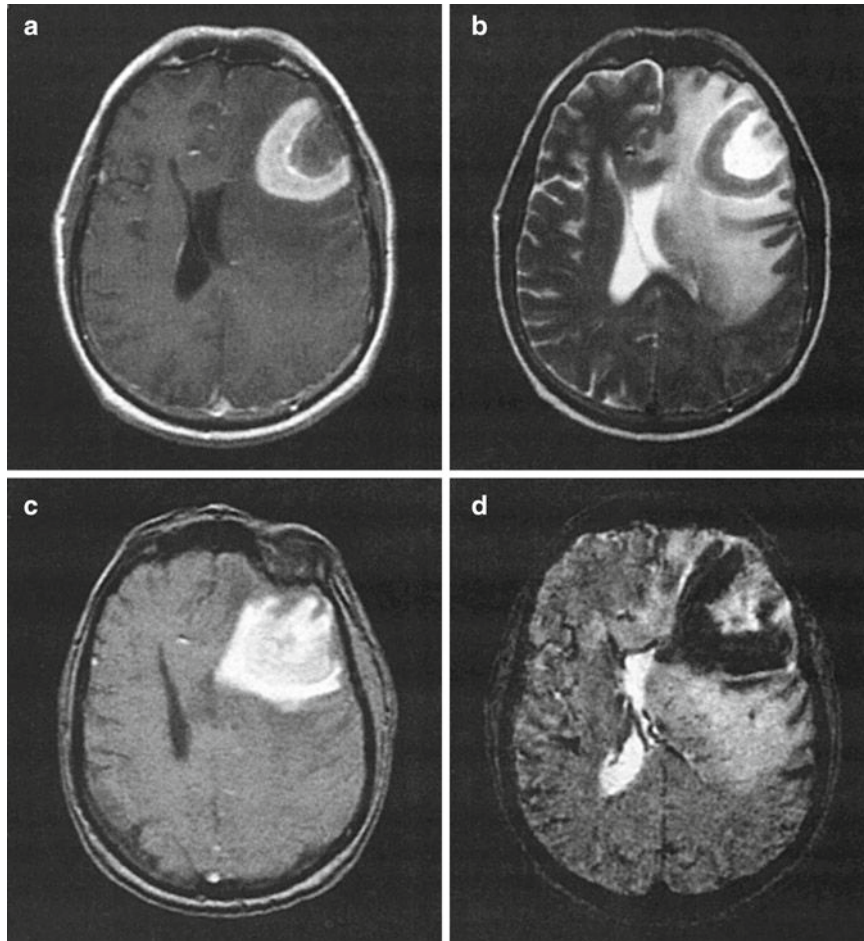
Representative images using ferumoxtran-10 in a patient with CNS lymphoma. (a) T1-weighted image with gadolinium (b) T1-weighted image 1 day after ferumoxtran-10 administration. (c) T2-weighted image prior to ferumoxtran-10 administration. (d) T2 GRE image 1 day after ferumoxtran-10 administration
